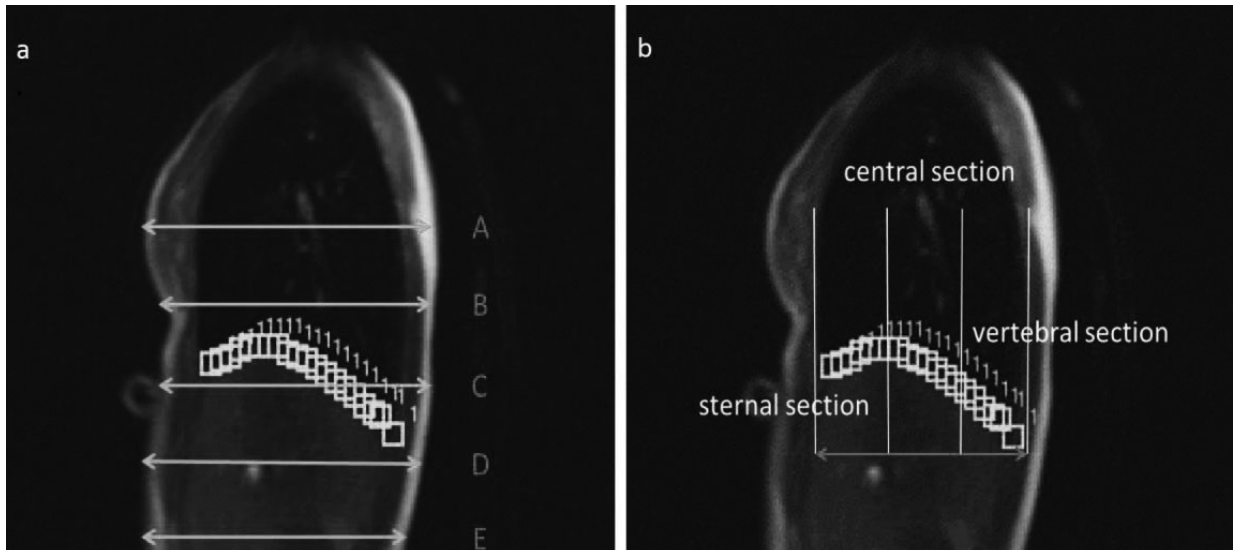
a. The sagittal images of the chest were divided into five segments as follows: A segment, position of the nipple; B segment, middle line between the A line at the nipple and the position at which the respiratory straps were placed during the MRI scan; C segment, position of the respiratory straps during the MRI scan (xiphoid); E segment, position at the height of the navel; and D segment, halfway between the C and E segments.
